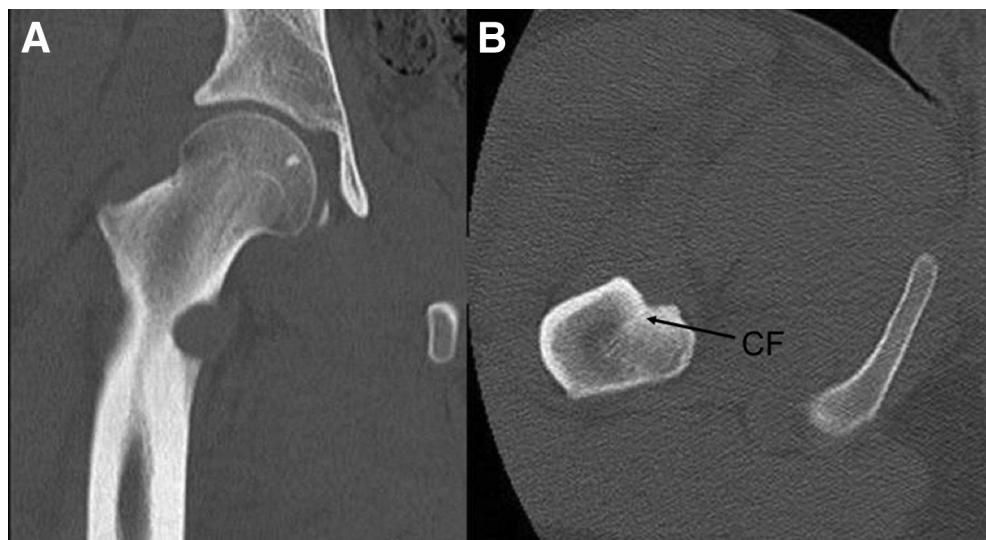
Postoperative computed tomography of the patient can be compared with the preoperative images in Figure 1. (A) Anteroposterior and (B) axial images of the right proximal femur postoperatively showing complete resection of the lesion and preservation of the calcar femorale (CF).
